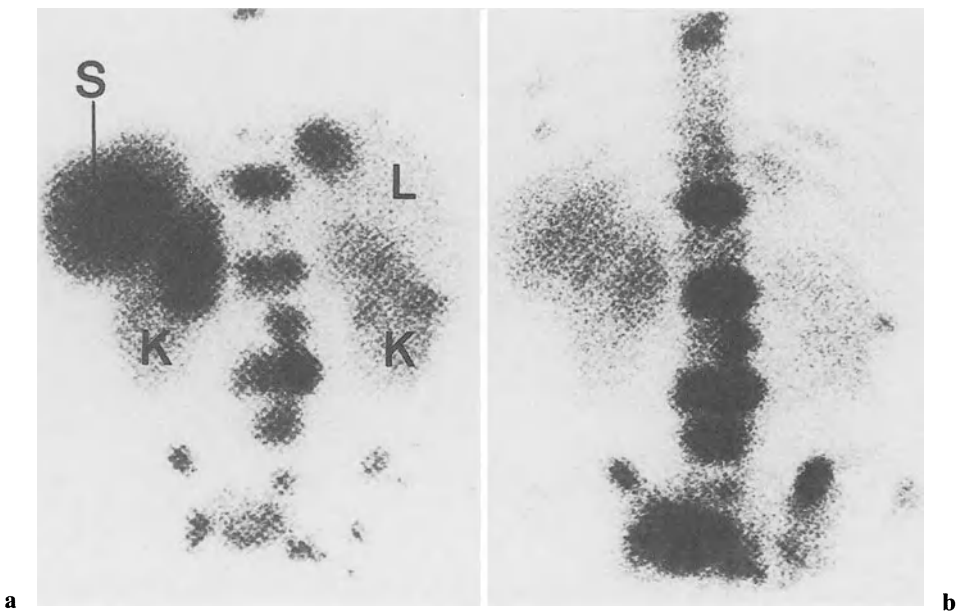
Dual isotope scintigraphy in patient with pancreas carcinoid. a Posterior view of somatostatin receptor scintigraphy shows multiple bony metastases and other metastases in liver and tail of pancreas. b Bone scan that is done at the same time using a ^{99m}Tc-labeled diphosphonate. In b there are multiple bony metastases in spine, ribs, and pelvis. Note the slight visualization of spleen and liver caused by the ¹¹¹In-labeled pentetreotide, which is uncommon on bone scans
